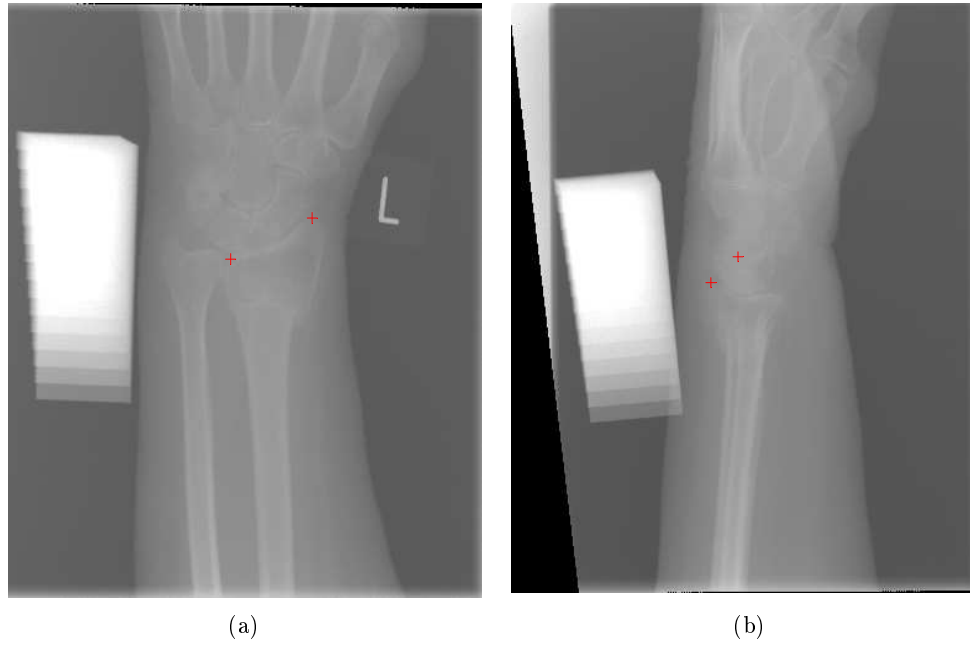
X-rays showing the anatomical landmarks used for image registration in a) the AP and b) the lateral X-rays.
